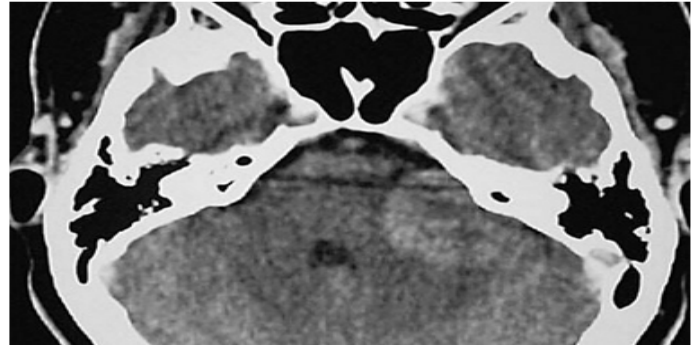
Axial CT section of the brain demonstrates heterogeneously enhancing left CP angle mass f/s/o Left sided Acoustic schwannoma
